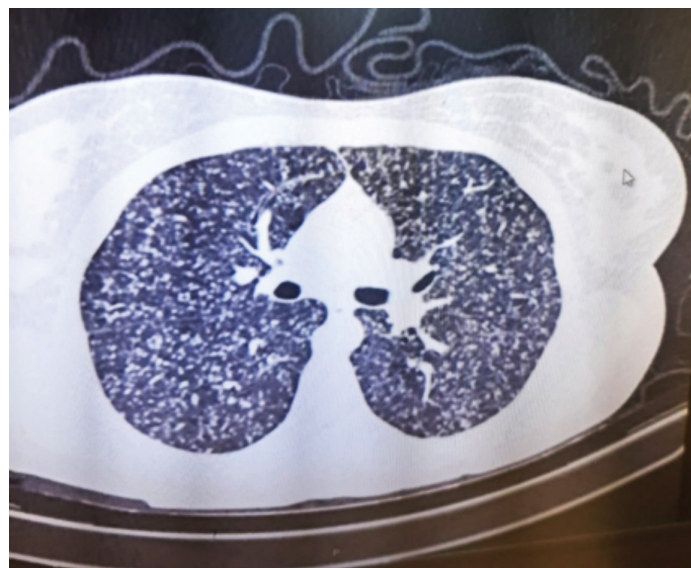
Thorax computed tomography image
